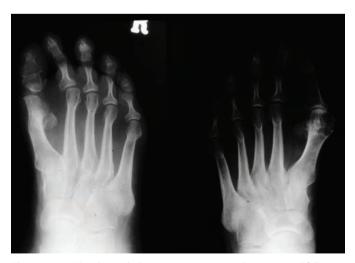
AP radiograph demonstrating excessive bone removal following Keller's excision arthroplasty
